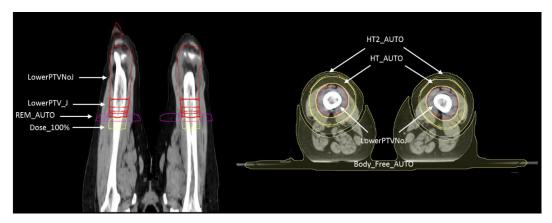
Frontal and transverse views of the main structures generated by the script on the lower-extremities CT.
